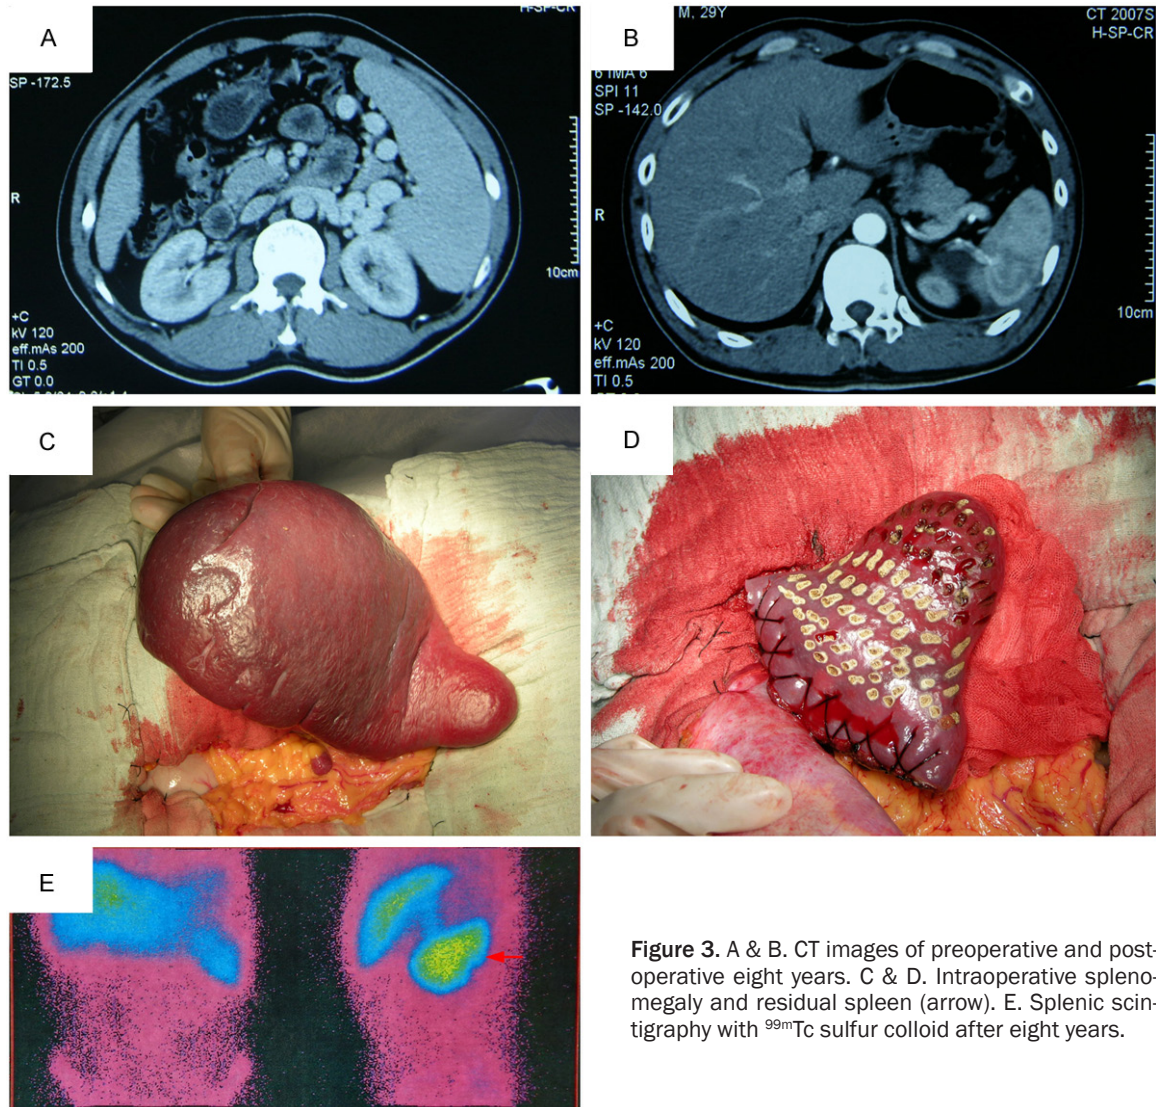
A & B. CT images of preoperative and post-operative eight years. C & D. Intraoperative splenomegaly and residual spleen (arrow). E. Splenic scintigraphy with ^{99m}Tc sulfur colloid after eight years.
